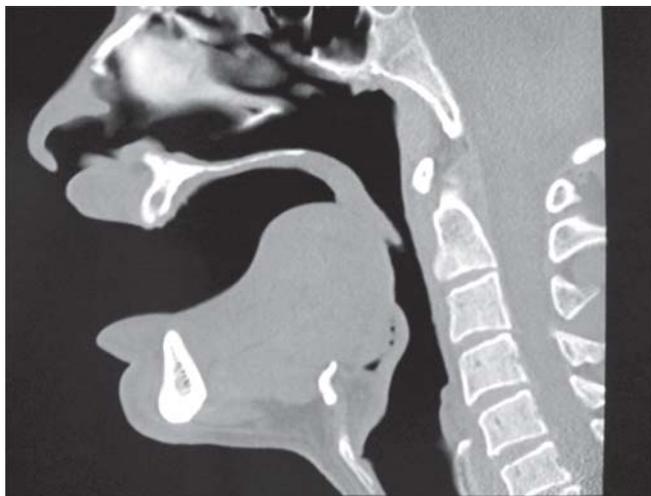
Multiplanar reformatted images obtained by CT. Anatomic position of each cross-sectional image are located by numbers
